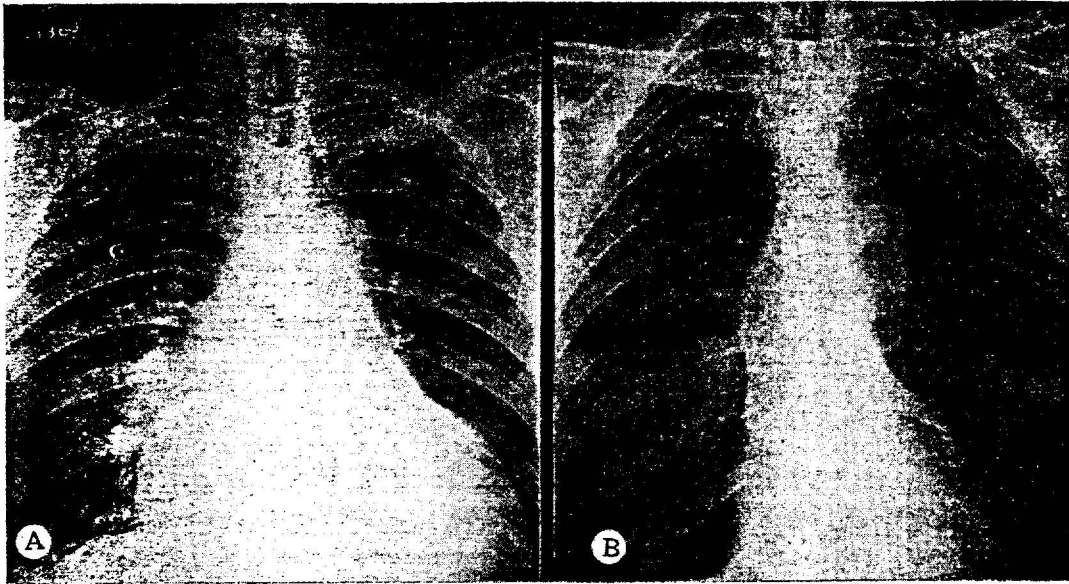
Roentgenograms of the chest taken before and three months after treatment with mecamlamine in a 57-year-old Negro man with malignant hypertension. Digitalis and mercurial diuretics were not used in treating this patient.
